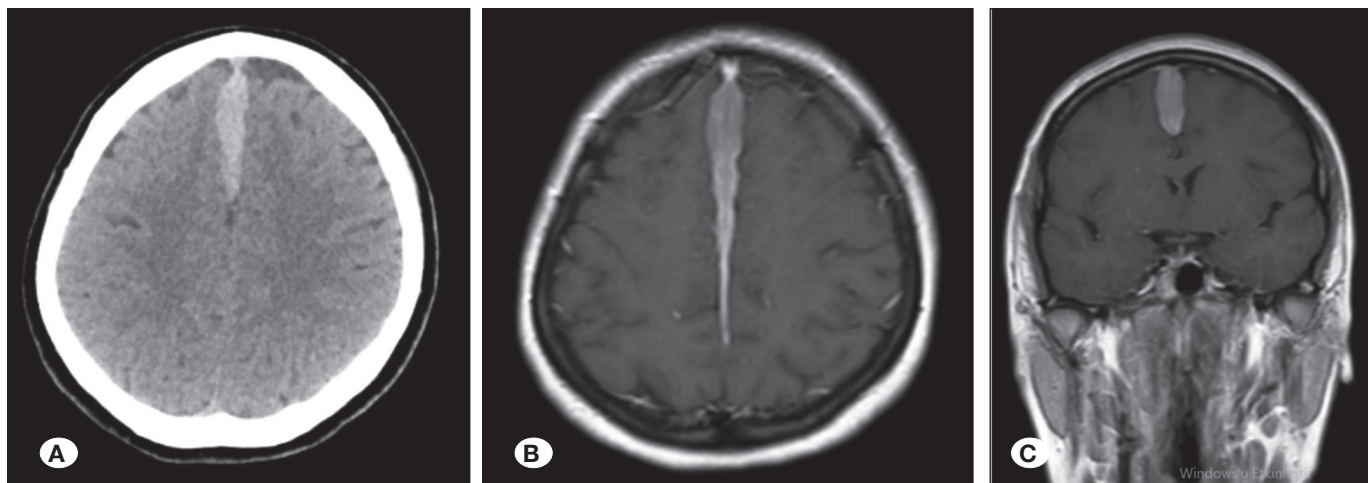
The patient's non-enhancing axial CT (A), gadolinium-enhanced axial (B), coronal (C) T1W MR images show a parafalcine extra-axial mass.
